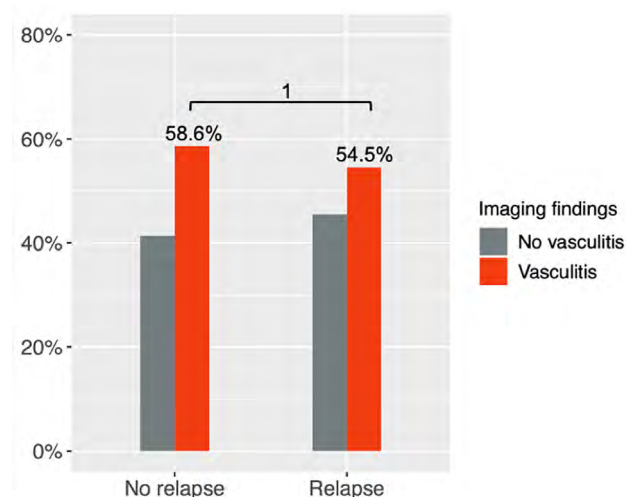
Signs attributable to active vasculitis on MRI and/or PET/CT in patients who remained in remission (N=29) compared to patients who relapsed (N=11).
